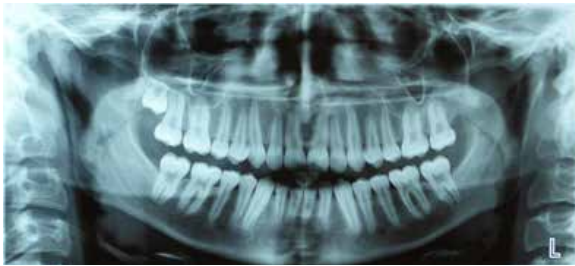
Posttreatment orthopantomograph and lateral cephalogram
